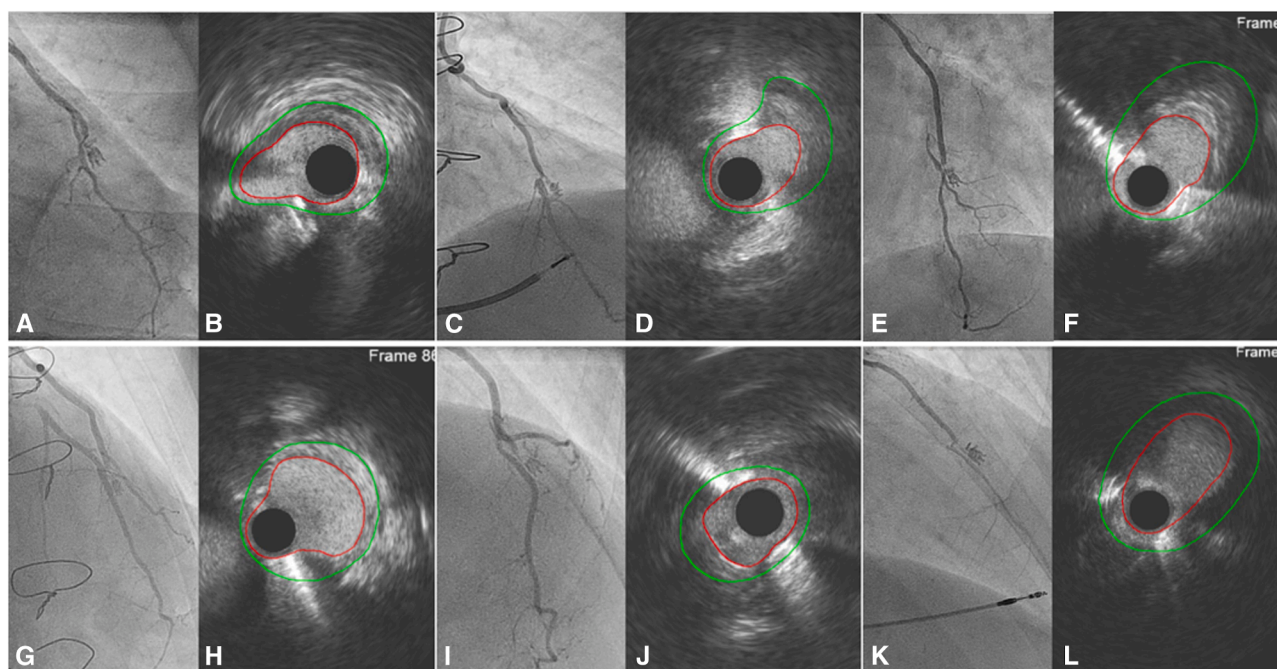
Coronary angiography (CAG) assessed as FitzGibbon B and corresponding intravascular ultrasound (IVUS) results of the left internal thoracic artery to left anterior descending coronary artery anastomosis in 6 individual patients. The *green line* depicts the vessel, and the *red line* is the measured lumen. A, CAG of patient 1. B, IVUS of patient 1. C, CAG of patient 2. D, IVUS of patient 2. E, CAG of patient 3. F, IVUS of patient 3. G, CAG of patient 4. H, IVUS of patient 4. I, CAG of patient 5. J, IVUS of patient 5. K, CAG of patient 6. L, IVUS of patient 6.
